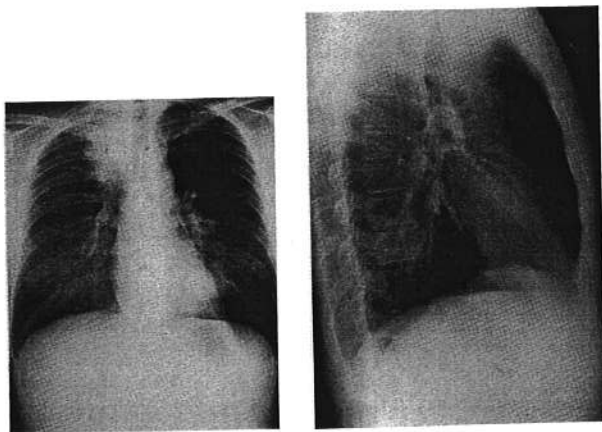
Posteroanterior (PA) and lateral chest roentgenogram.
